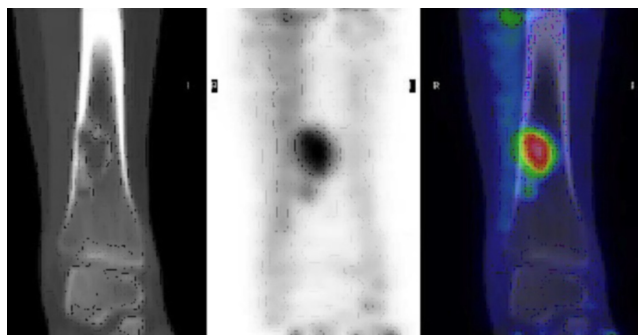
14-year-old girl with nonossifying fibroma. Lucent lesion (left) is noted in the distal right tibia on coronally reformatted CT. Increased uptake is again noted in this lesion on coronal F18-FDG PET (middle) and F18-FDG PET/CT fusion image (right).
